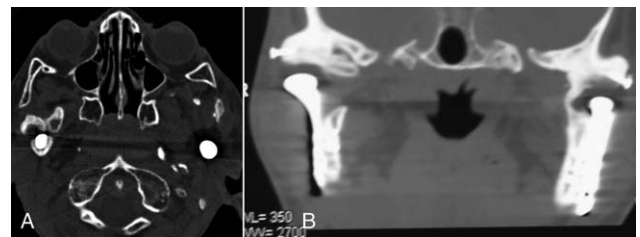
(A) Axial CT scan showing heterotopic ossification around the right TMJ condylar head prosthesis. (B) Coronal CT image showing heterotopic bone mass on the medial aspect of the condylar head prosthesis, extending to the medial surface of the glenoid fossa. CT, computed tomography.
